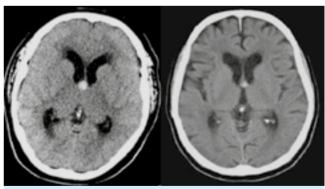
CT scans showing colloid cysts from two different patients.
